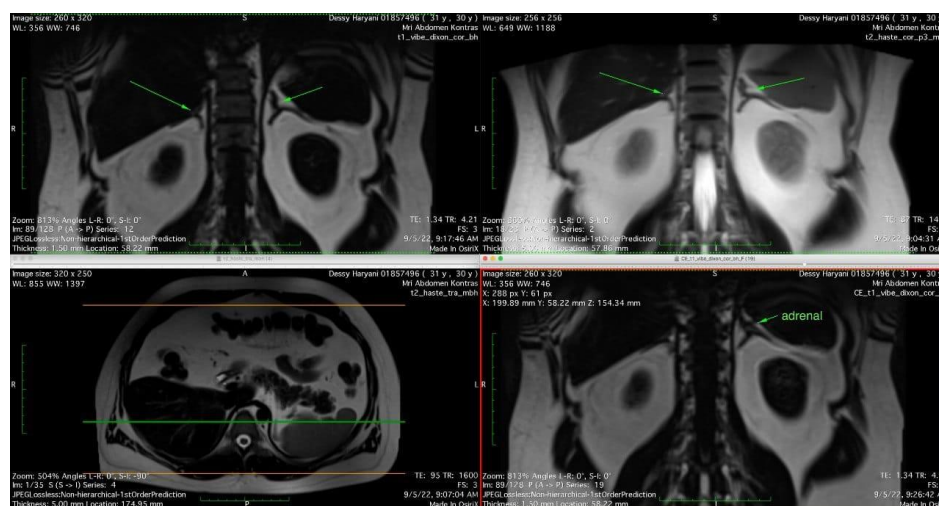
Abdominal MRI examination with contrast
